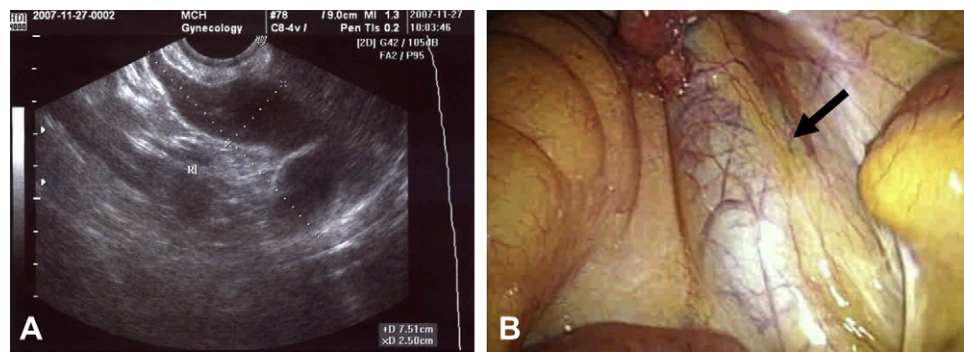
(A) Ultrasonography revealed a sausage-shaped 7.5-cm × 2.5-cm mass with septum and fusiform tail. (B) Laparoscopic findings of megaureter. Arrow: ureter.
